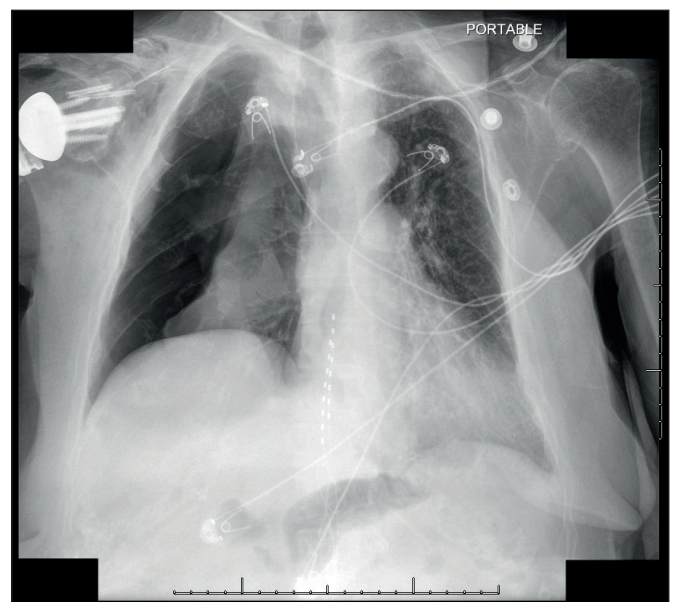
Post-operative chest X-ray with a large right-sided pneumothorax with near complete right lung collapse.
